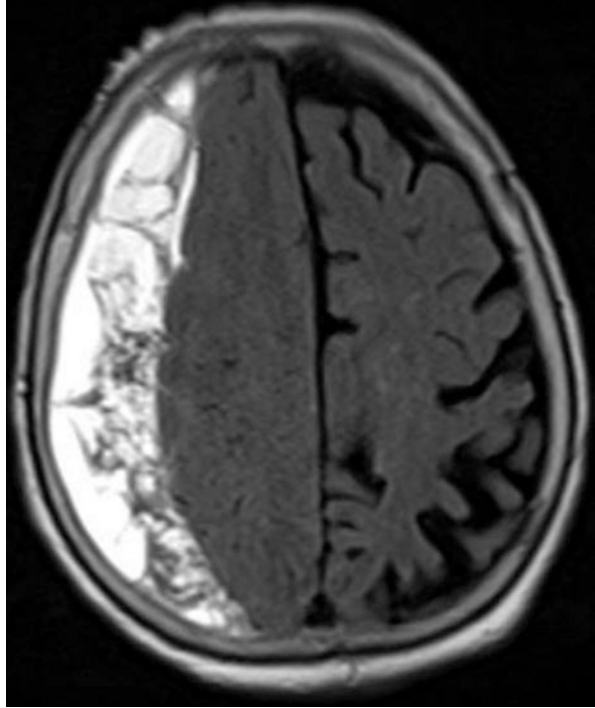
Preoperative T2-weighted MRI showing multiple intrahematomatous loculations with a hypointense web-like structure within the organized CSDH over the right cerebral hemisphere
